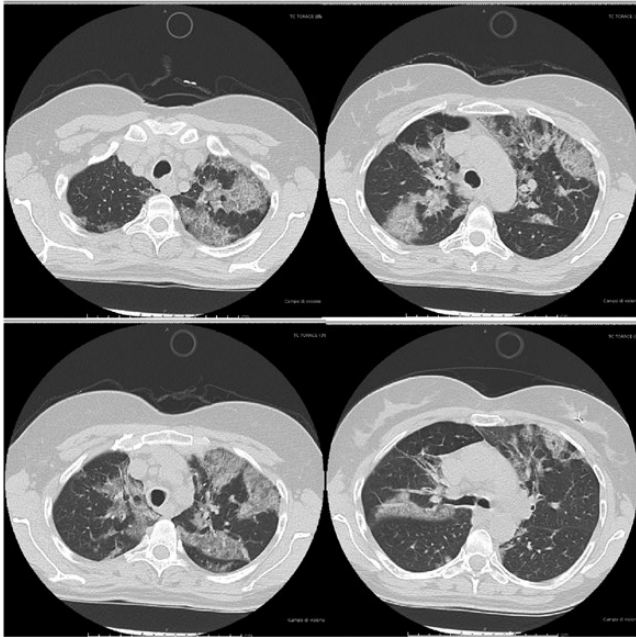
High-resolution computed tomography scans of the chest from upper to lower lobes showing multiple areas of parenchymal thickening with a ground glass appearance and concomitant thickening of the inter- and intralobular septa in the upper lobes bilaterally, with several parenchymal consolidations with nodular morphology prevalent in the right lower lobar site.
